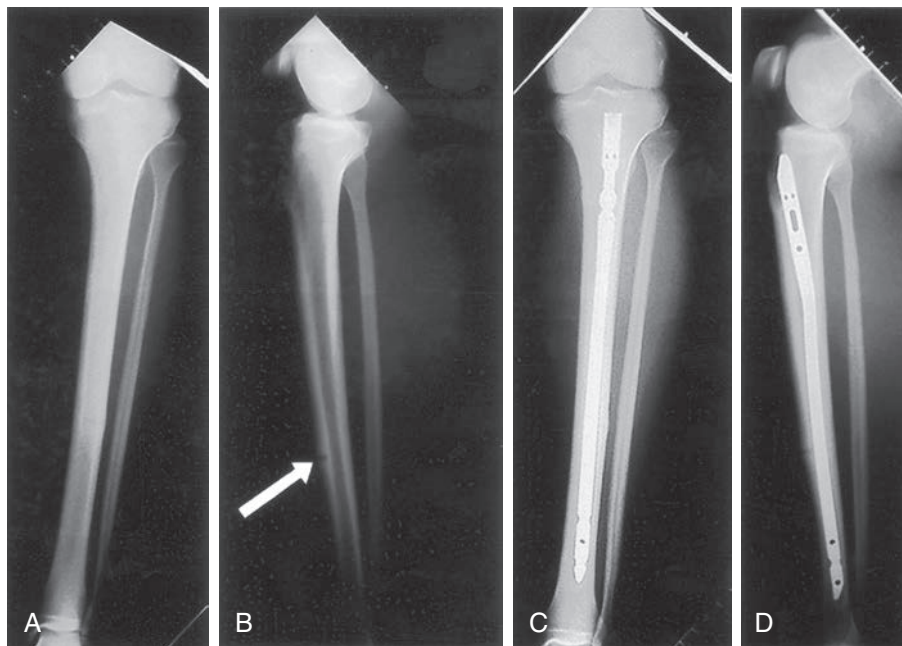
(A and B) Preoperative radiographs of a male runner who presented with a midanterior cortex tibial stress fracture, also referred to as a “dreaded black line” which is visible in the lateral radiograph (B). (C and D) Because of the severity of the fracture, intramedullary nailing was required. As demonstrated in the 2-month postoperative radiographs, the fracture healed completely without the need for bone grafting.
